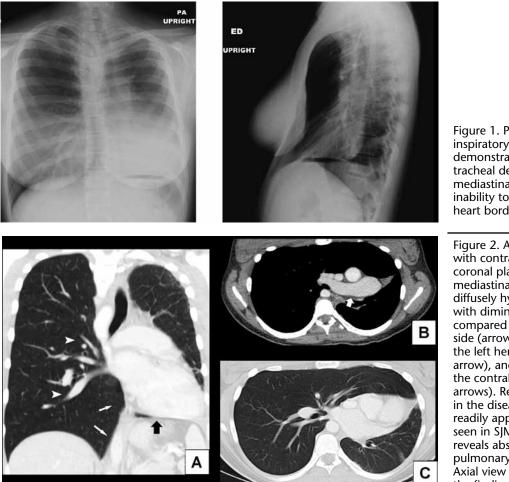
Posterior-anterior inspiratory chest radiograph demonstrated significant tracheal deviation with mediastinal shift to the left and inability to perceive the left heart border.
